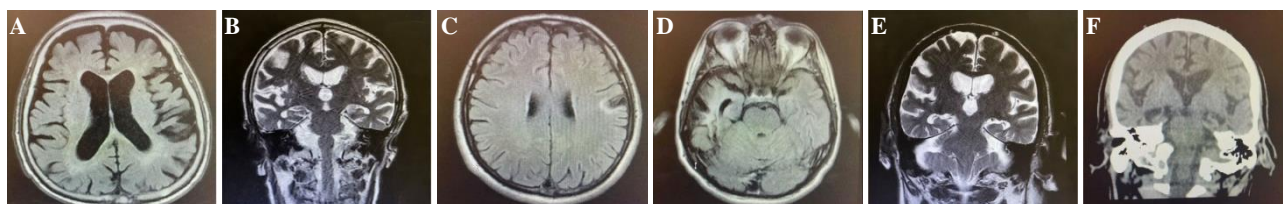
Magnetic resonance imaging of cases, A) case 1, B) case 2, C-D) case 3, E) case 4, F) case 5
